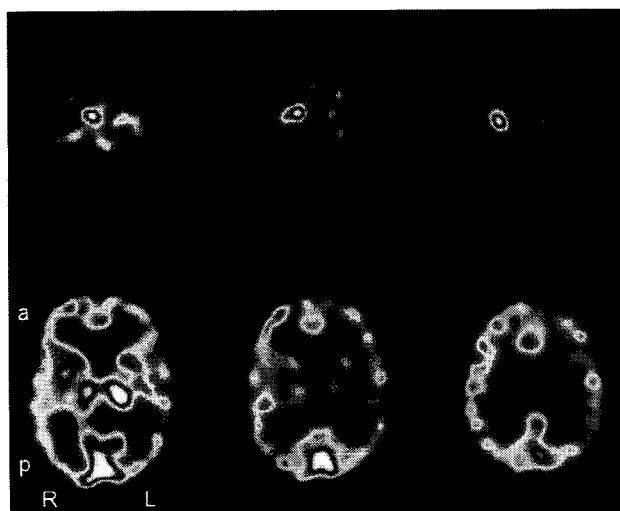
SPECT of the proband (III:1): Top: ^{123}I -FP-CIT SPECT at age 45 years revealed markedly decreased presynaptic dopamine reuptake capacity in basal ganglia bilaterally, but clearly more so on left side. Bottom: $^{99\text{m}}\text{Tc}$ -HMPAO SPECT at age 47 years revealed reduced cortical blood flow, most markedly in the parietal lobes. This reduction was more prominent in the left hemisphere, where some reduction of cortical blood flow also occurred in the temporal lobe and the lateral portion of the frontal lobe. R, right; L, left; a, anterior; p, posterior.
